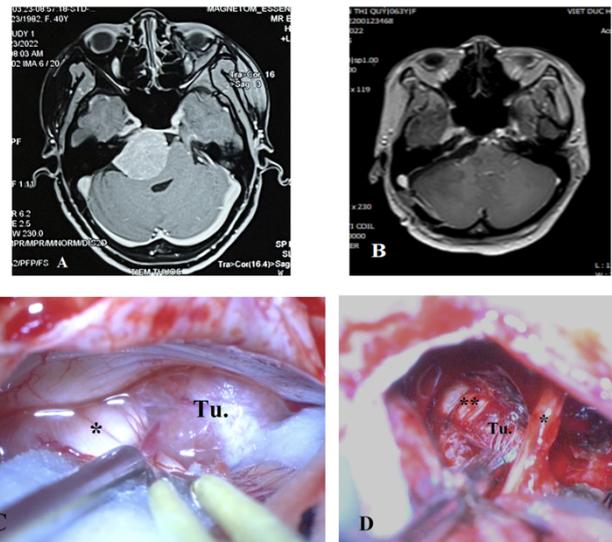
A preoperative axial T1-weighted Gd-enhanced MRI (A) revealing a CPA meningioma anterior to the IAC. A postoperative axial T1-weighted Gd-enhanced MRI (B) demonstrate total resection of the tumor via the retrosigmoid approach. Intra-operatively, the tumor displaced the facial nerve posteriorly (C) and the process of tumor removing through the level between the CN V and VII-VIII (D). Tu. Tumor, * VII-VIII complex,  CN V.
